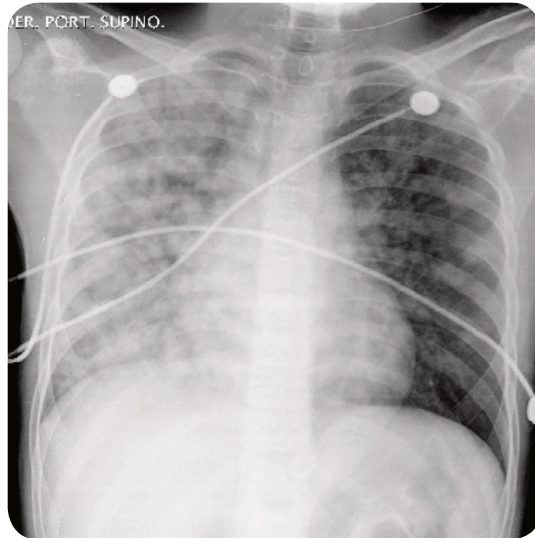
A chest radiograph demonstrating acute pulmonary edema in an individual who ascended to 2700m.
